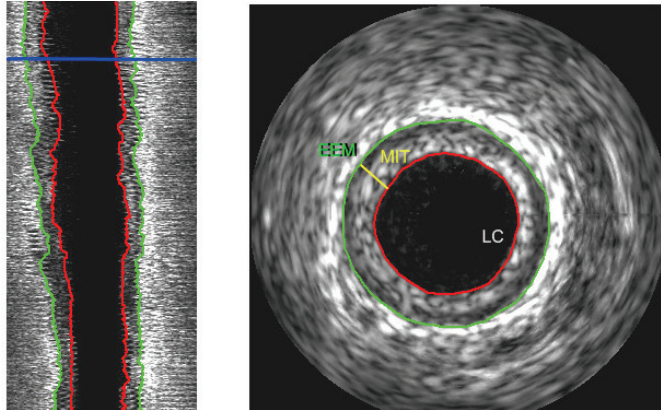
Example of tracing of contours following intravascular ultrasound (IVUS) acquisition.
